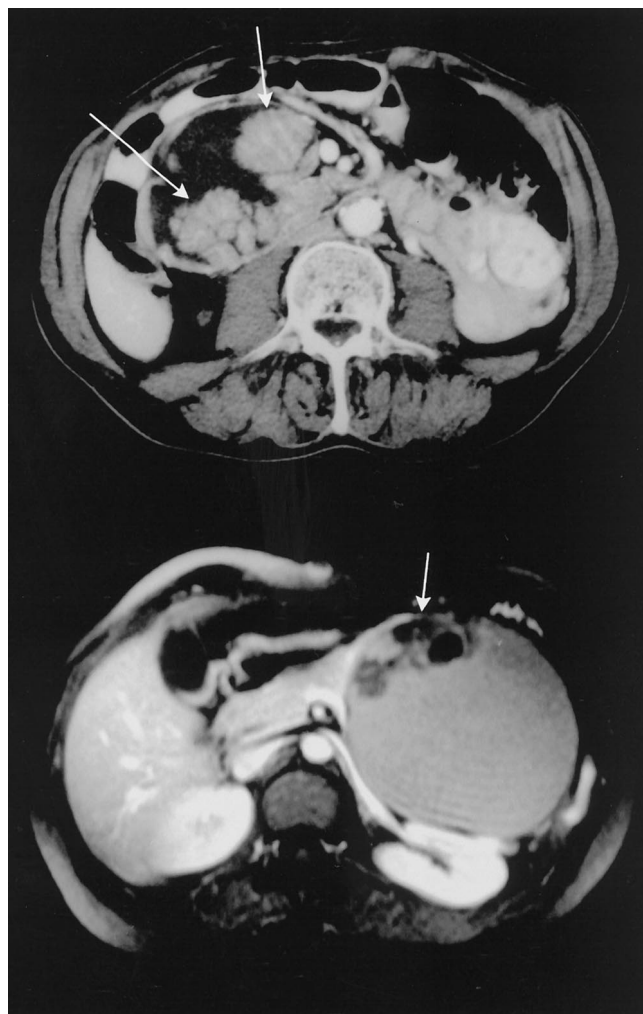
(Upper) Computed tomography scan of the abdomen shows marked dilation of the main pancreatic duct with solid papillary projections in this benign intraductal mucin hypersecreting tumor. (Lower) Magnetic resonance imaging of the abdomen shows a large cystic mass with mural nodules in the tail of the pancreas (mucinous cystadenoma).
